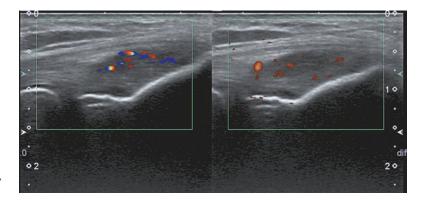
Tendinosis: right common extensor tendon with significantly increased internal flow on Doppler; normal tendons demonstrate no internal flow on Doppler: *right* image is color Doppler, *left* power Doppler
